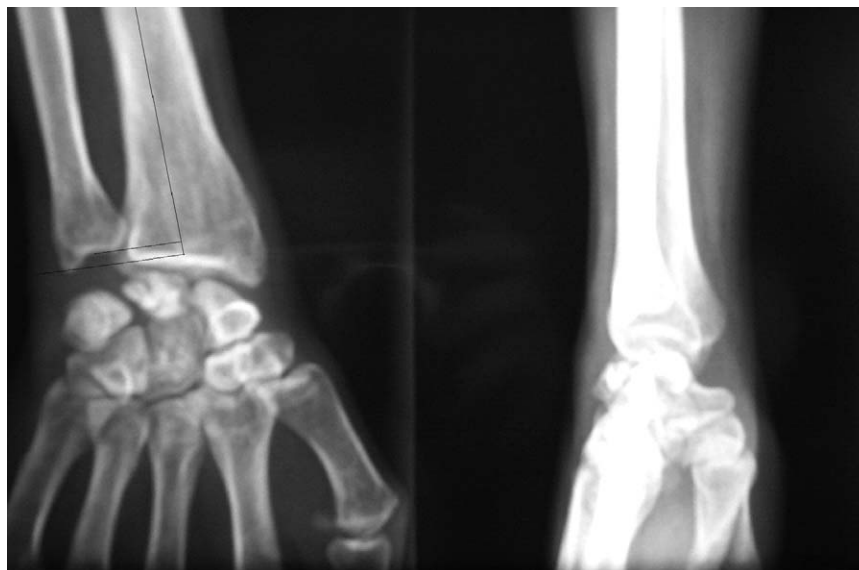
Standard radiography, frontal and lateral view: osteonecrosis of the lunate bone, negative ulnar variance.
